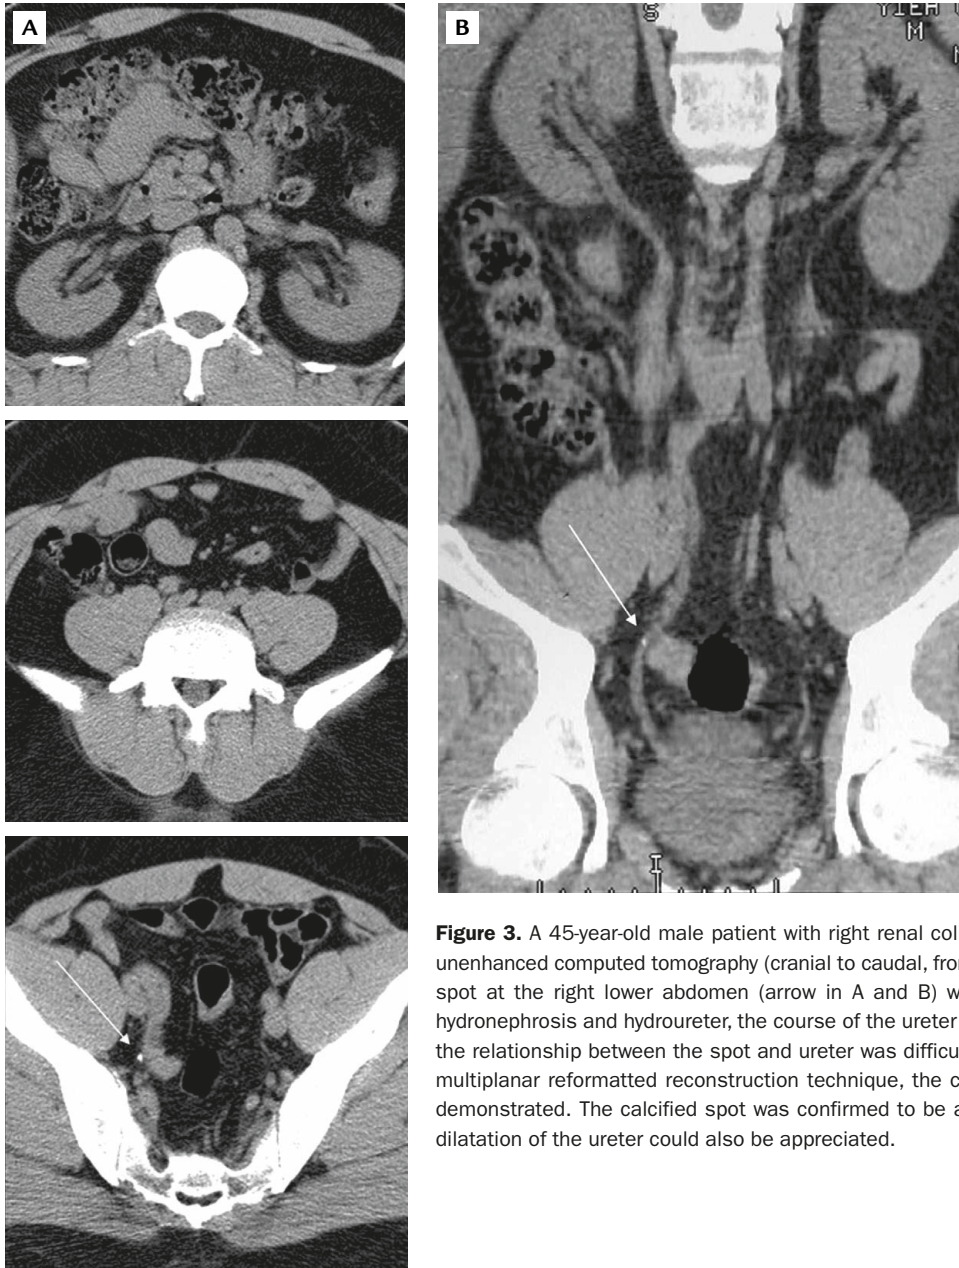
A 45-year-old male patient with right renal colic. (A) On serial axial images of unenhanced computed tomography (cranial to caudal, from top to bottom), a tiny calcified spot at the right lower abdomen (arrow in A and B) was identified. However, without hydronephrosis and hydroureter, the course of the ureter could not be demonstrated and the relationship between the spot and ureter was difficult to define. (B) With the curved multiplanar reformatted reconstruction technique, the course of the ureter was clearly demonstrated. The calcified spot was confirmed to be a ureter stone, and the minimal dilatation of the ureter could also be appreciated.
